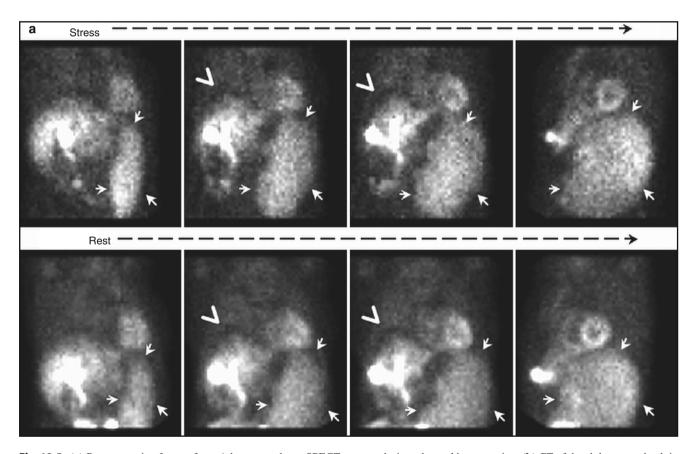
(a) Representative frames from Ad stress and rest SPECT images of an 82-year-old woman who underwent this study as a part of preoperative cardiac evaluation prior to abdominal surgery. The raw images reveal massive splenomegaly (*small arrows*) and ascites (*large arrow heads*). The patient had history of agnogenic myeloid
